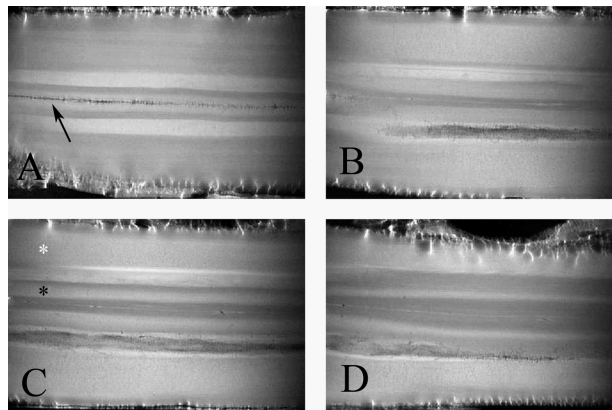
MRI sections in the horizontal (frontal) plane, from anterior (A) to posterior (D). All slices show the longitudinal organization of the spinal cord, including the hyper-intense area of Wallerian degeneration and the longitudinal extension of dorsal horn cavity. The laterally fading MR signal is due to the weakening magnetic field at the extremities. (A) Beginning at the mid-line and moving laterally, the hyper-intense, degenerating anterior corticospinal tract (long arrow), followed by white matter, then by the even more intense signal of the anterior horn grey matter, and finally by the antero-lateral white matter. (B) The heterogeneously hypo-intense dorsal horn lesion in the region of lamina VI. (C) Hyper-intense signal in the comma tract of Schultze (fasciculus interfascicularis, black asterisk) and the lateral corticospinal tract (white asterisk). From publication 3, page 185.
